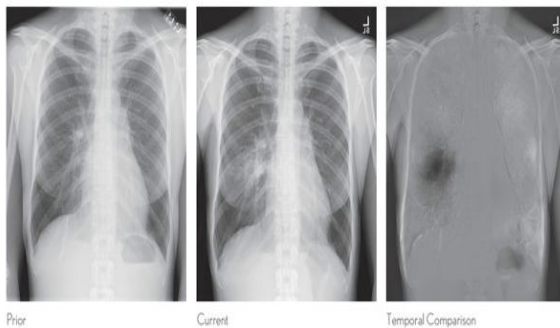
Rivera in Chest X-Ray Temporal Comparison Software Highlights Differences in Chest X-Rays over Time
